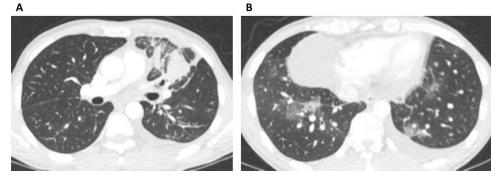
Lymphangitic carcinomatosis associated with *ALK*+ lung cancer. Representative axial CT images are taken from a 43-year-old male never smoker who presented with (A) dominant left upper lobe mass with surrounding lymphangitic carcinomatosis and (B) additional areas of lymphangitic carcinomatosis in the lower lobes.
